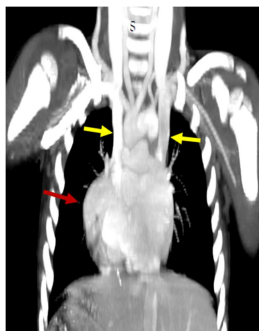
Thoracic CT in coronal section, mediastinal window, with PDC injection showing two right and left superior vena cavae (yellow arrow), heart on the right (red arrow).
